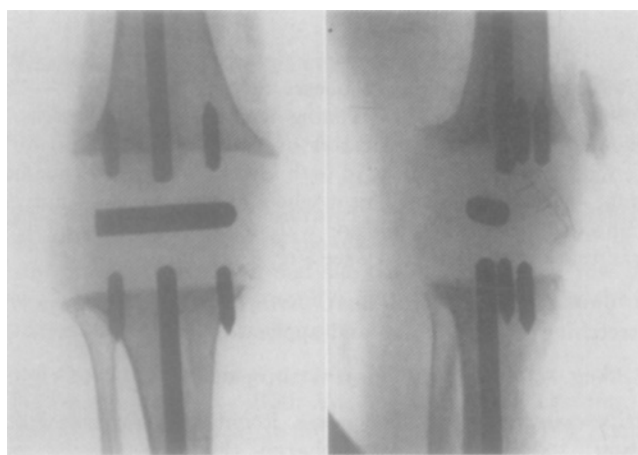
Case 4: roentgenograms of right knee 10 days after arthroplasty.
